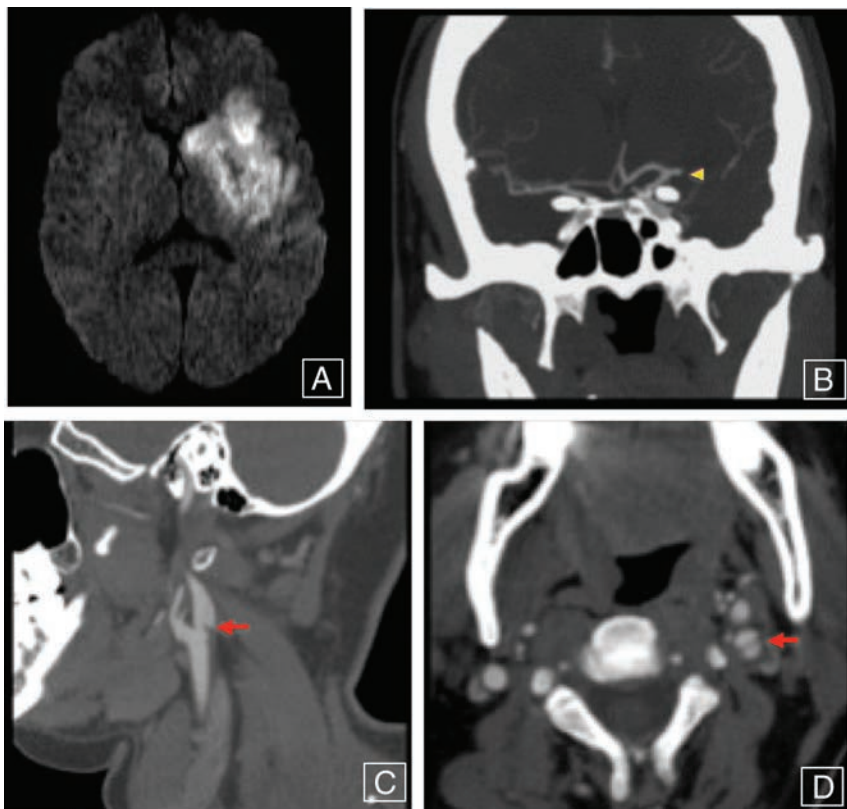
A patient presenting with right-sided weakness demonstrating an acute, large left MCA territory infarct as seen on diffusion-weighted imaging (A), with coronal CTA MIP image (B) showing abrupt occlusion involving the M1 segment of the left MCA (yellow arrowhead). Sagittal and axial neck CTA images (C and D) reveal a shelf-like intraluminal protrusion arising from the posterior wall of the left carotid bulb (red arrows), compatible with a carotid web.
